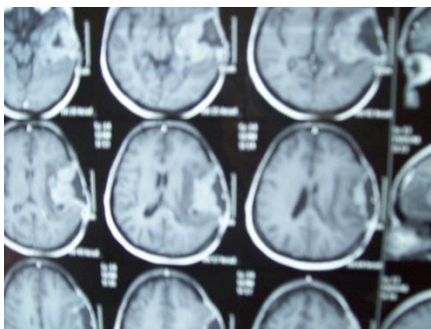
CT scan revealed a recurrent non enhancing hypodense mass 5.6x4.6 cm in left fronto-parietal lobe causing midline shift.
